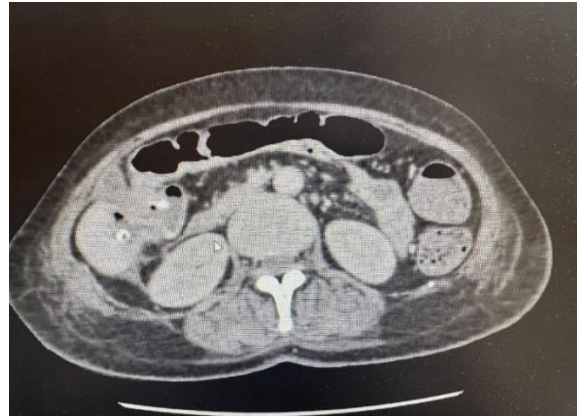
Axial CT scan showing a digestive fistula
